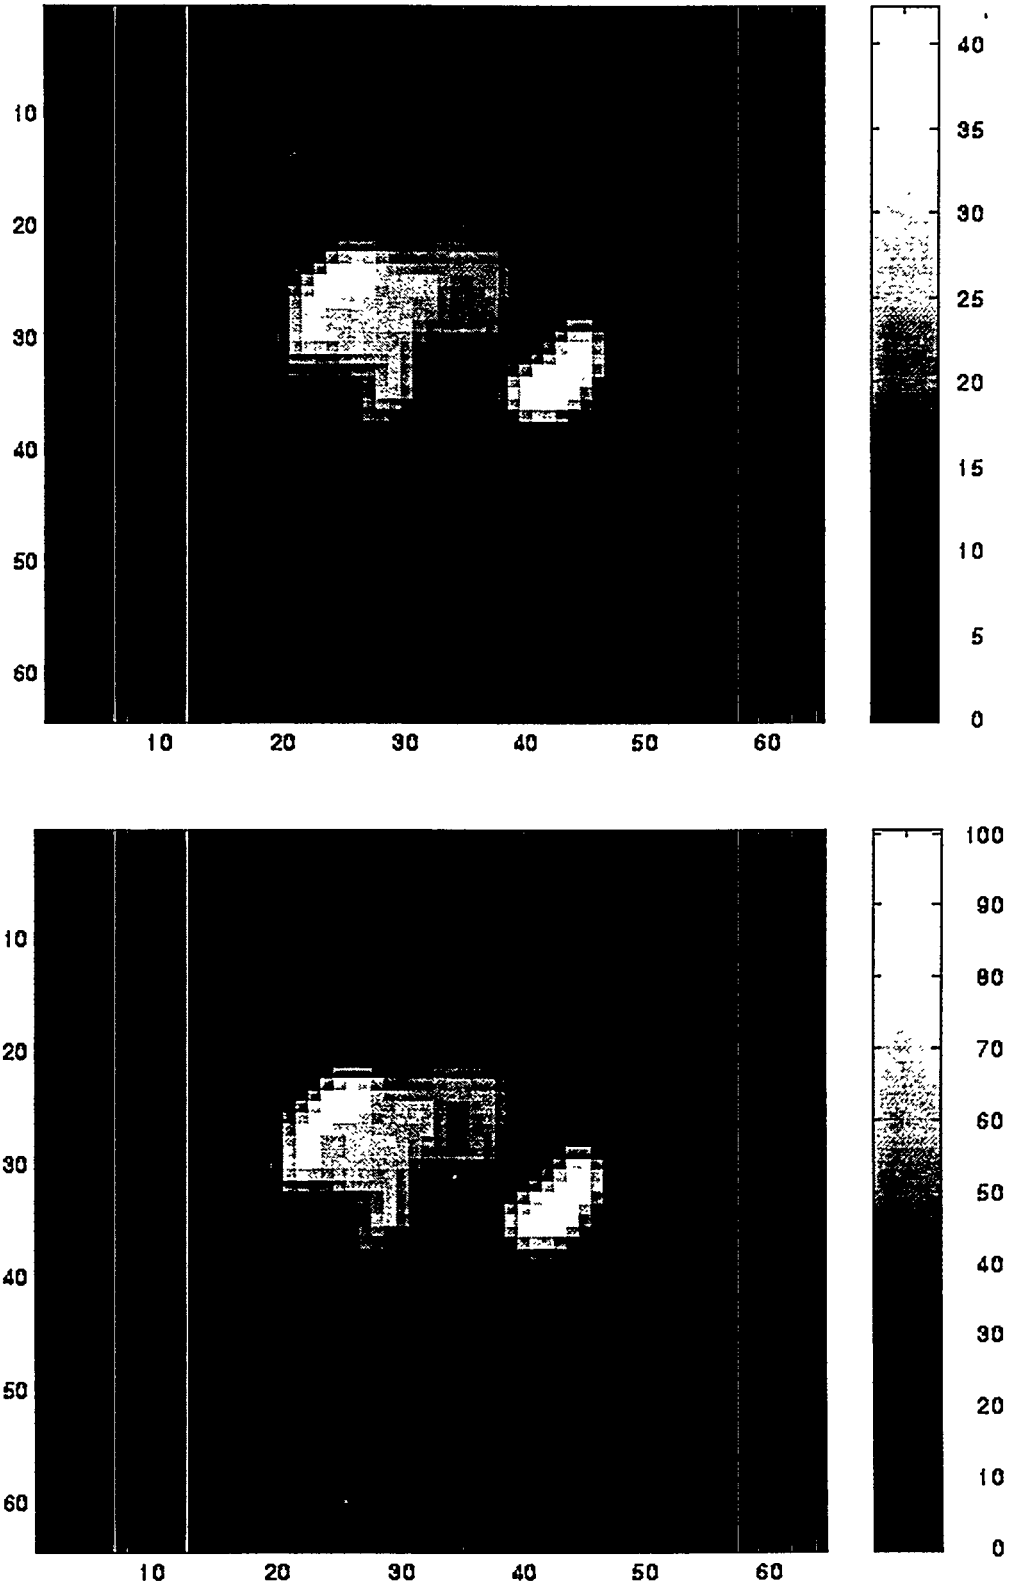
Relative dose distribution for Slice 10 (above) along with the original SPECT image (below).
